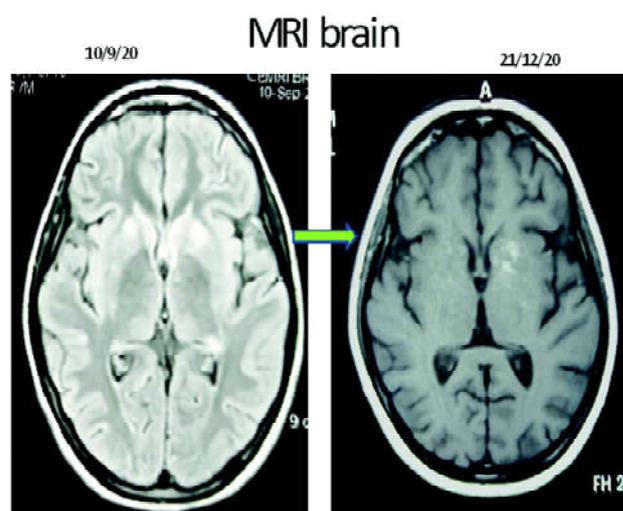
Showing comparison between the images of two MRI of brain at the level of Basal ganglia. The left side image (10.09.2020) is showing hyper-intensity in the ganglio-thalamic region bilaterally. The right side image (21.12.2020) is showing normal intensity with some residual changes in the left caudate nucleus.
